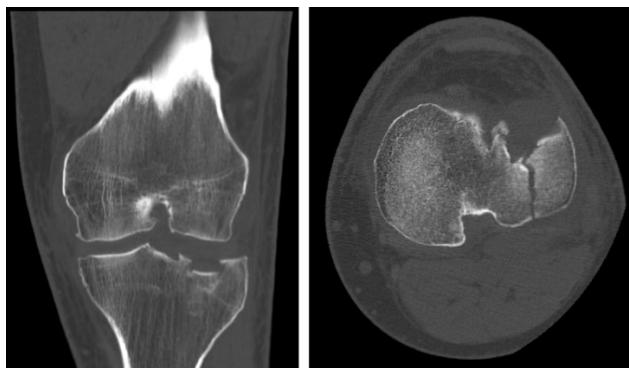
Computed tomography of the tibial plateau fracture.
